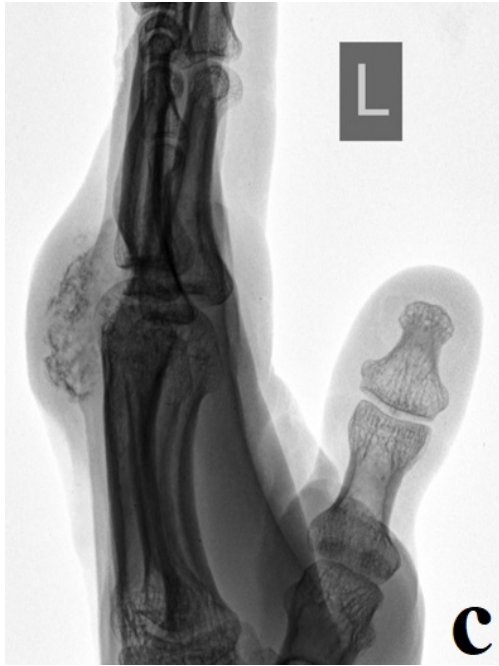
x-rays in side projections*
